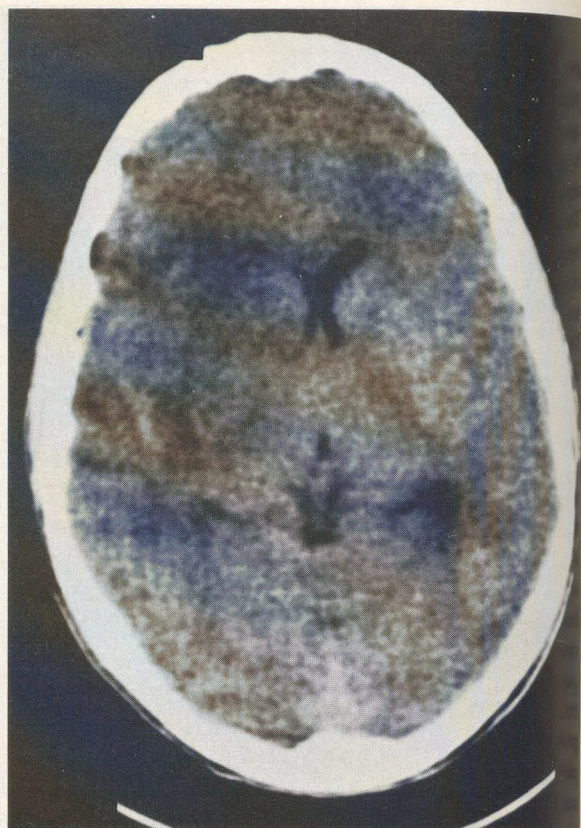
Follow-up computed tomographic brain scan with contrast 9 days after the initial study demonstrating right-sided infarction and cytotoxic edema involving the frontal, temporal, and parietal lobes.
